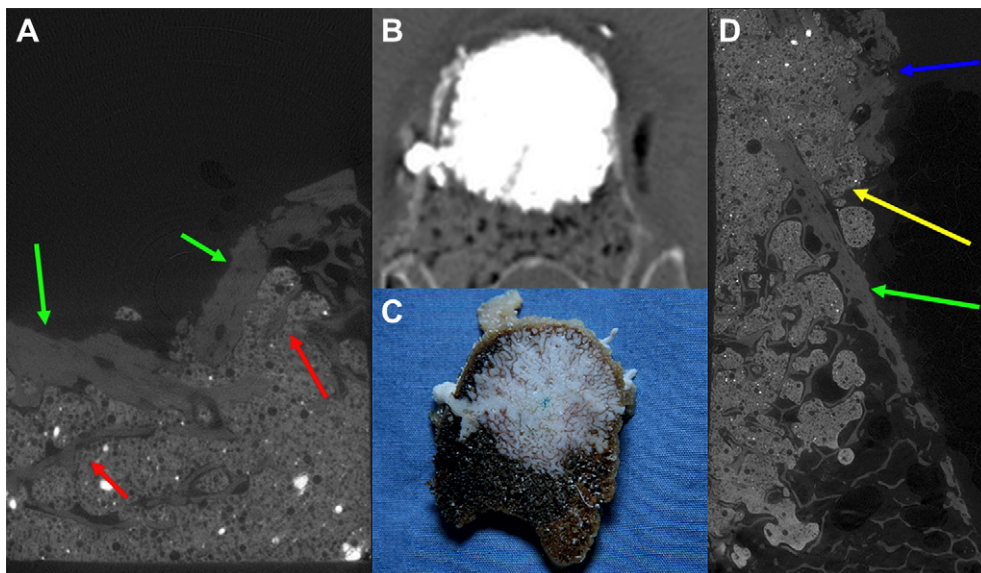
(A and D) Micro-computed tomography (CT) images, (B) CT axial cut, (C) and still axial cut images of the same segment. (A) Cement interdigitates through broken fragments (red arrows), holding both fragments and cortices close together (green arrows). (B and C) Note the interdigitation of cement through the trabecular bone and the leakage through the external cortex. (D) Cement leakage (yellow arrow) through a fractured cortex (green and blue arrows). Note the displacement of the fractured cortex (blue arrow) by the cement.
